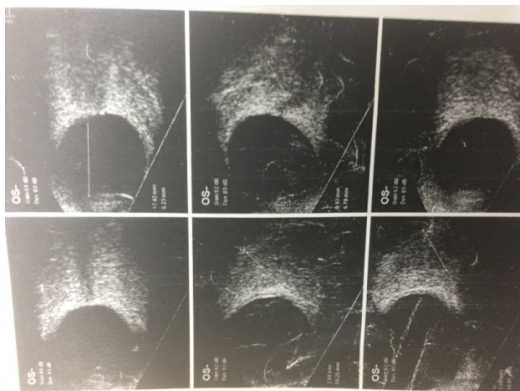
Extraocular muscle thickening of the same patient on B scan ultrasonography(OS).
